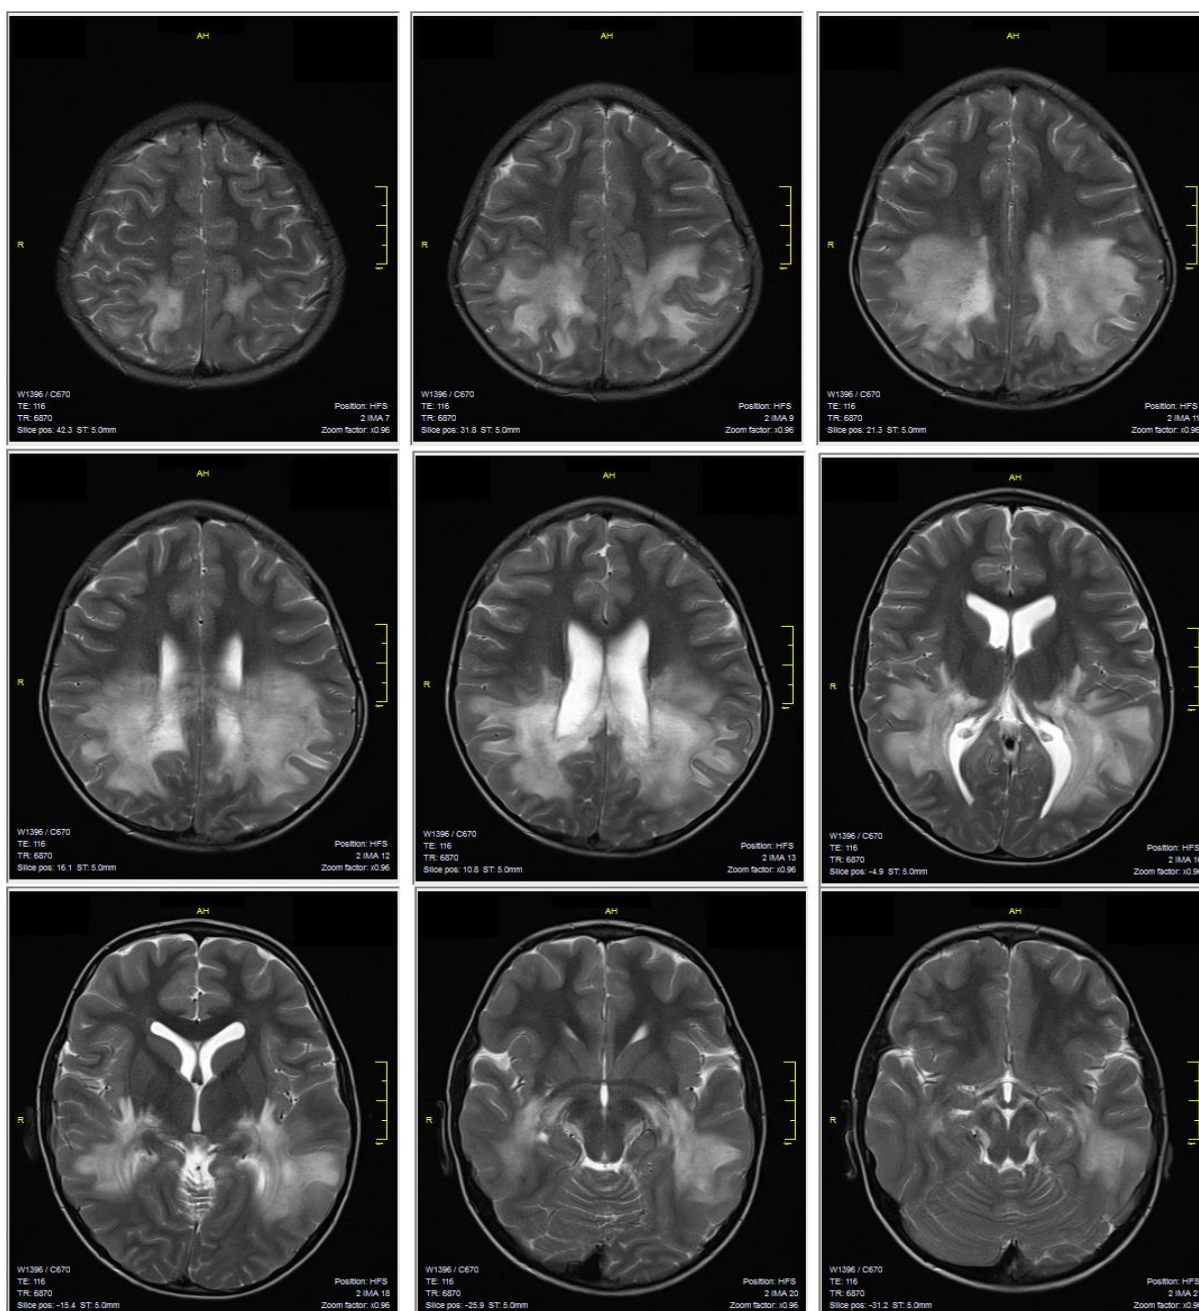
MRI T2 weighted images in axial projection displaying the brain demyelination lesions
